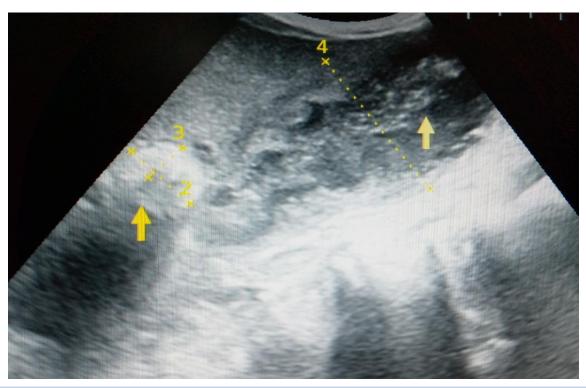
Abdominal ultrasonogram showing the thick and trabeculated wall of the gallbladder with intraluminal nodularity or hump-like appearance, heterogeneous sludge (right arrow), peripheral and circumferential hypoechoic halo of acute cholecystitis and the impacted calculus with posterior acoustic shadow (left arrow).
